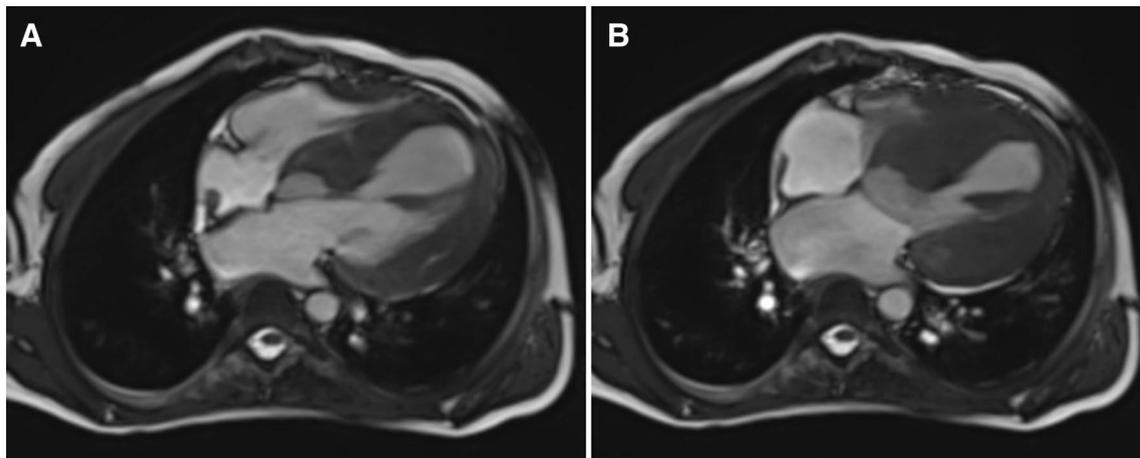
The MRI of a 14 year old child with a hypertrophic cardiomyopathy caused by a Noonan syndrome with lentigines in a diastolic and b systolic four-chamber view is depicted
